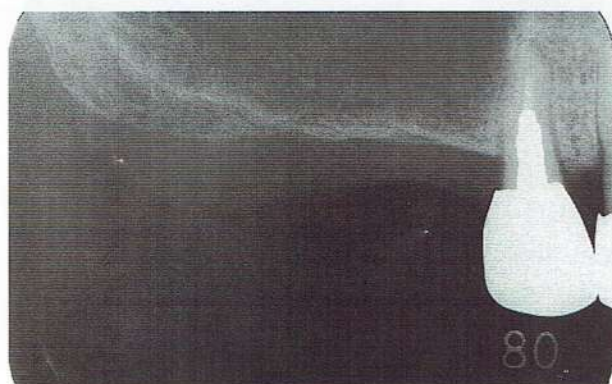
Preoperative radiograph of right first and second molars
